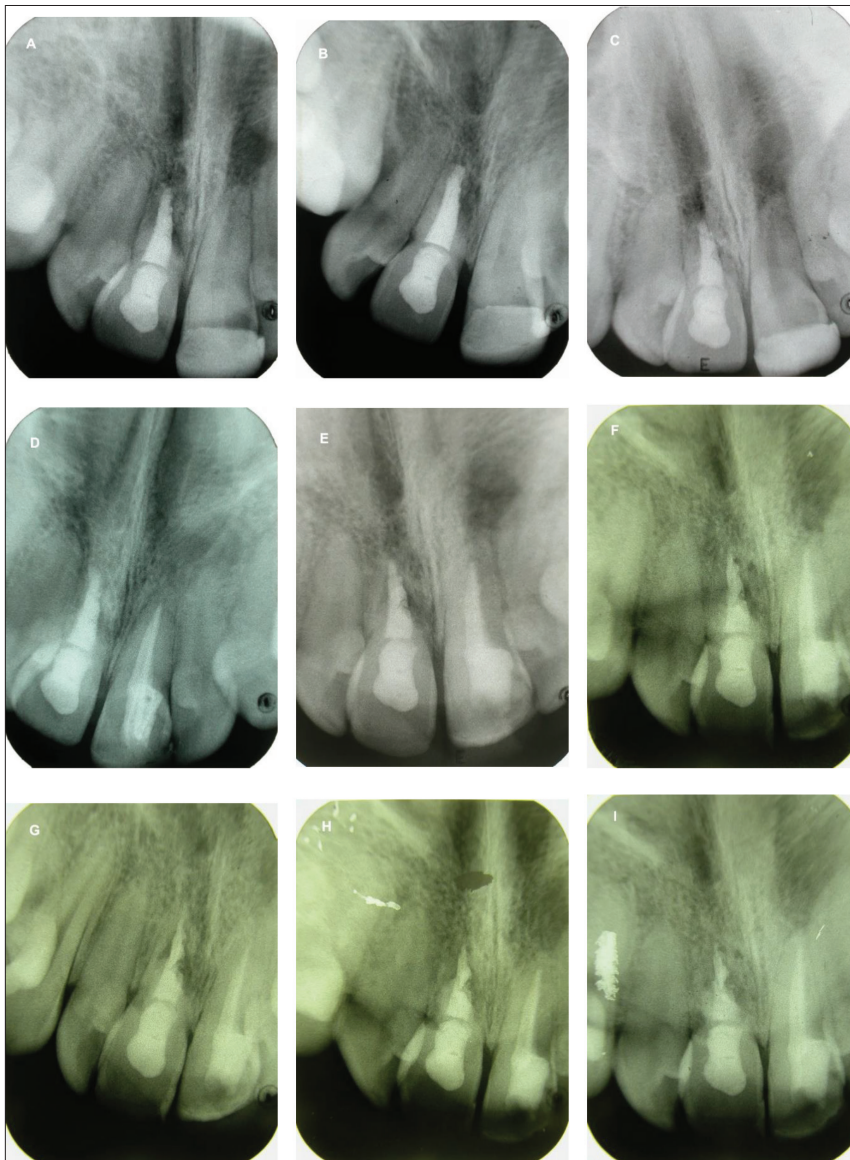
Radiographic follow-up after: (A) two years; (B) three years; (C) four years; (D) five years; (E) six years; (F) seven years; (G) eight years; (H) nine years; and (I) 10 years
